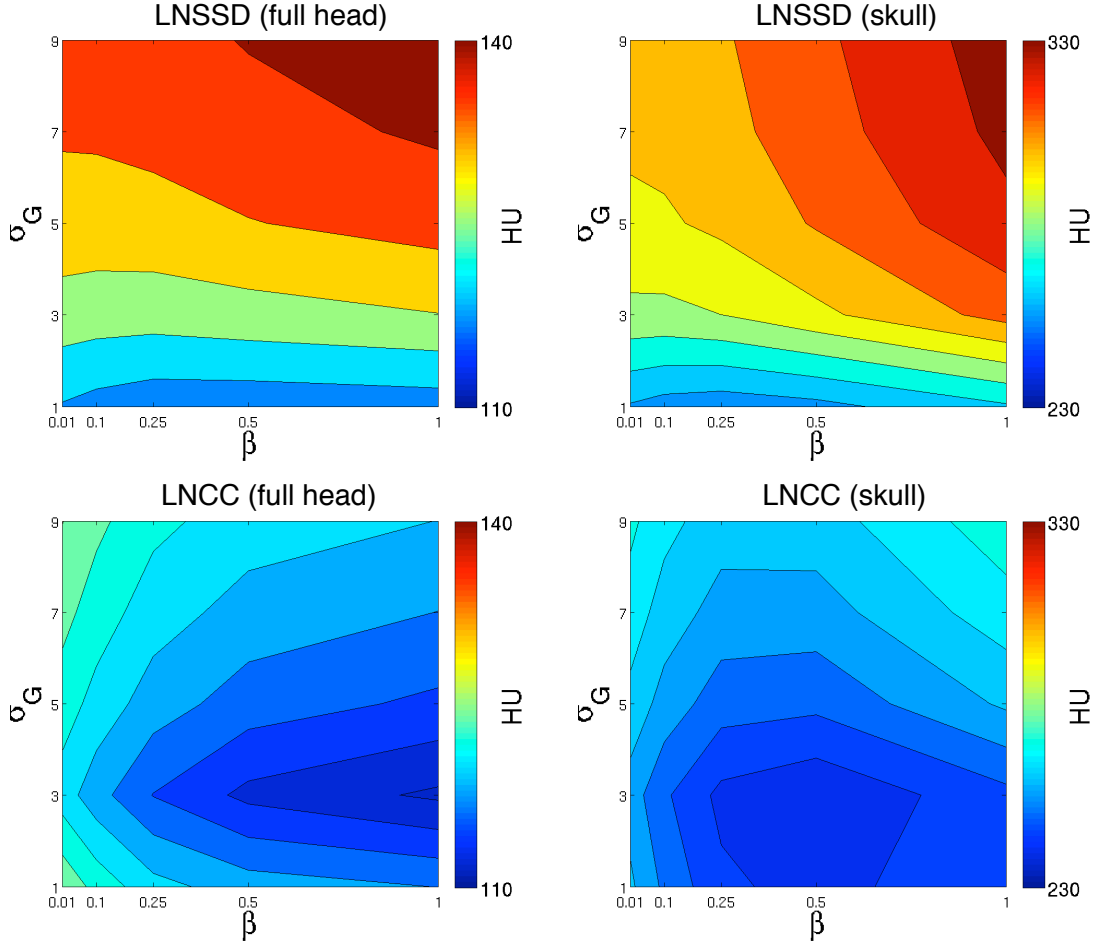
Average MAE between the reference CT and the pseudo CT generated using the LNCC and LNSSD as similarity metrics for varying values of σ_G and β . The best parameters are obtained for the LNCC, with $\sigma_G = 3$ and $\beta = 0.5$, giving an average MAE of 113 HU for the full head and 240 HU for the skull region of interest.
